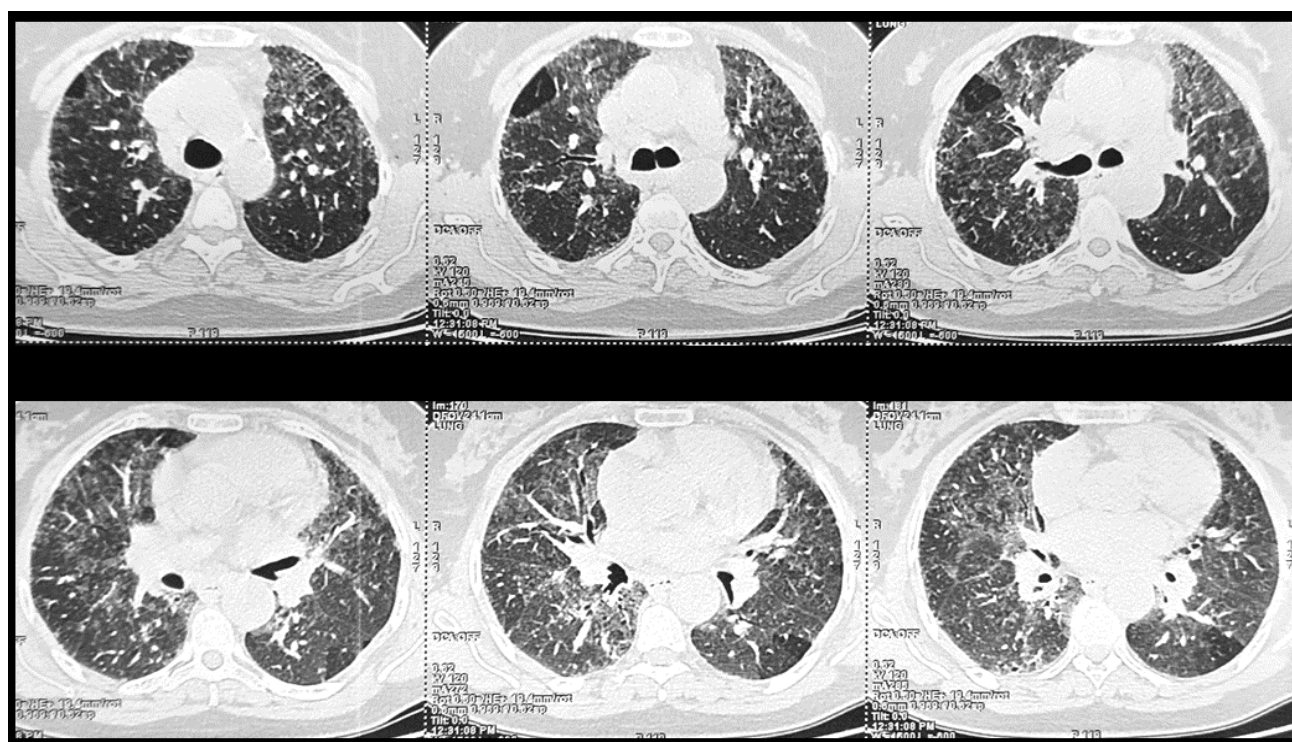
High-resolution computed tomography of Case 2. Typical fibrotic hypersensitivity pneumonitis showing the three-density pattern and fibrotic abnormalities
